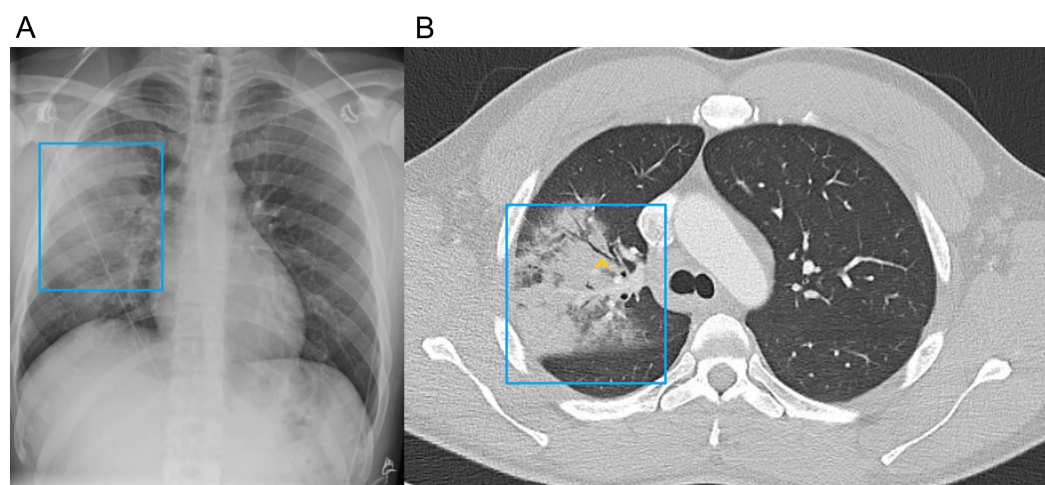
Consolidation. (A) A Chest radiograph showing consolidation in a patient admitted with pneumonia (blue box). (B) Computed tomography (CT) showing consolidation (blue box) with air bronchogram (yellow arrow) in the same patient—source author.
